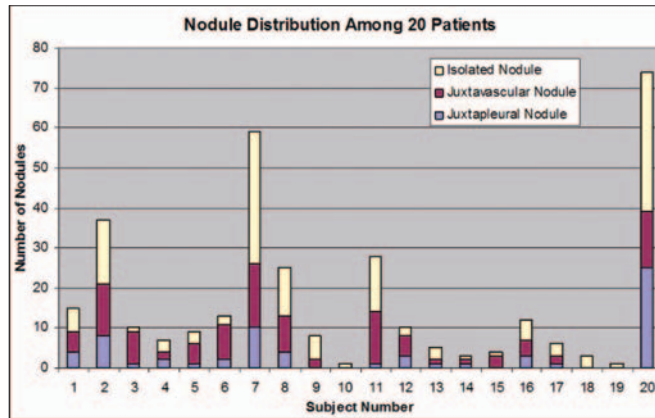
Nodule distribution among the 20 chest CT scans
